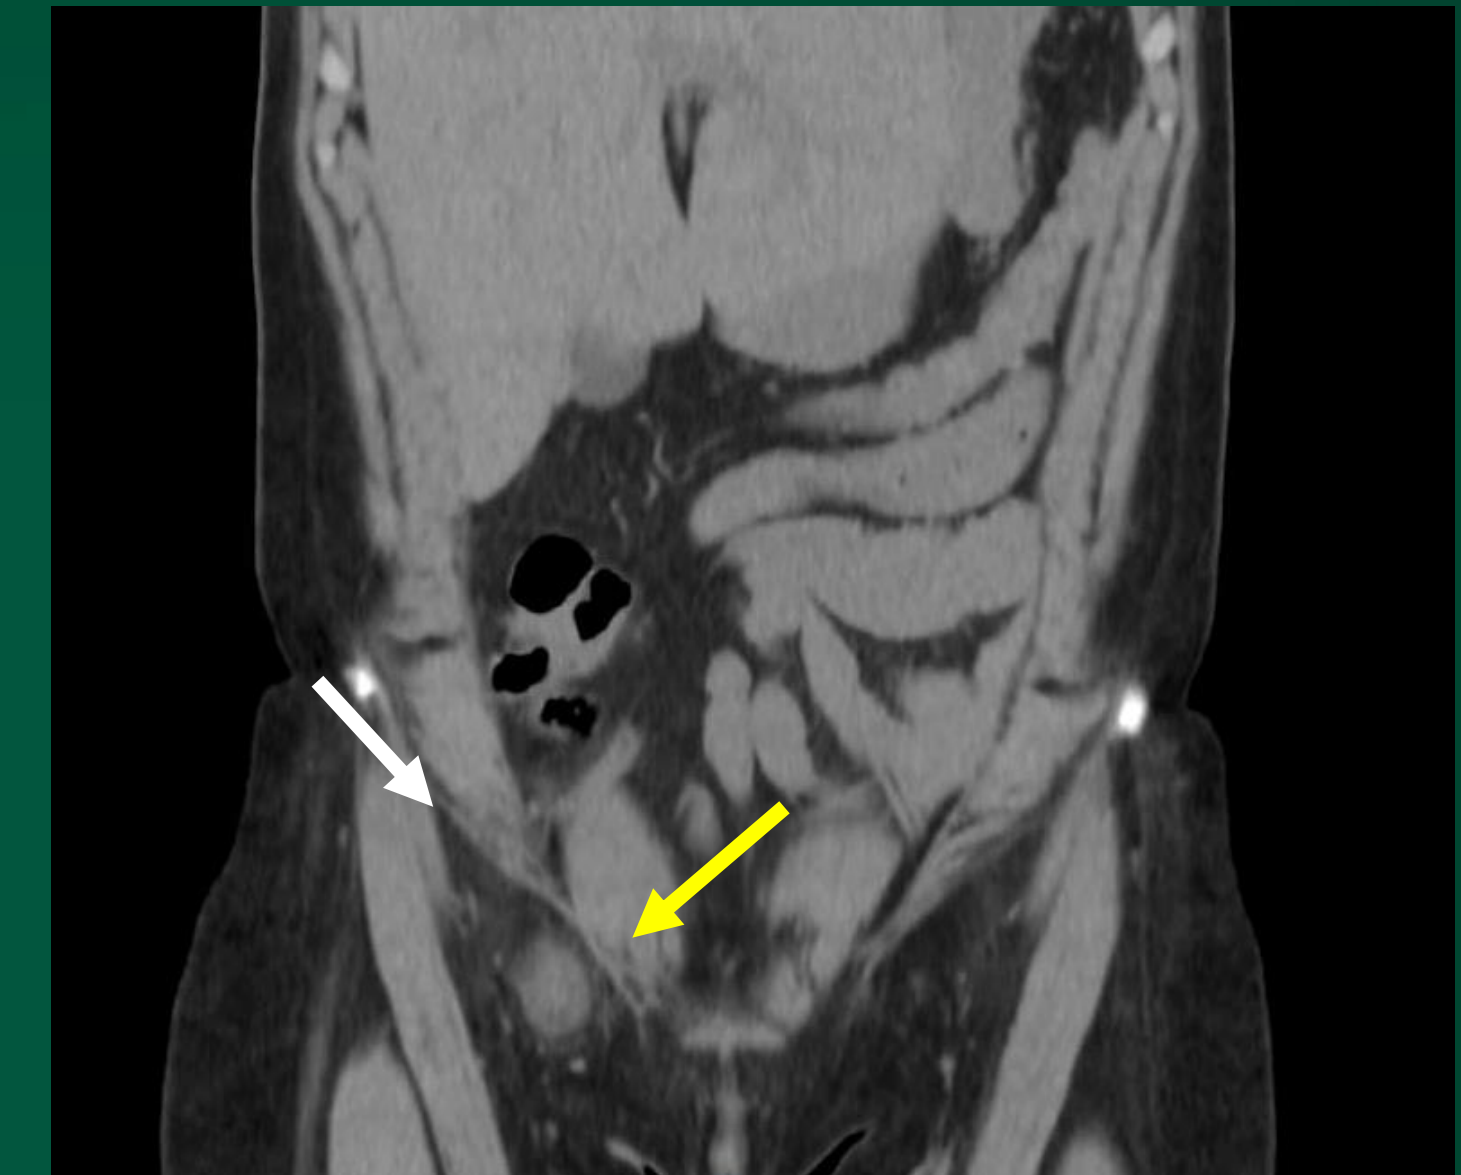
Coronal CT showing right femoral hernia (yellow arrow) and inguinal ligament (white arrow)
